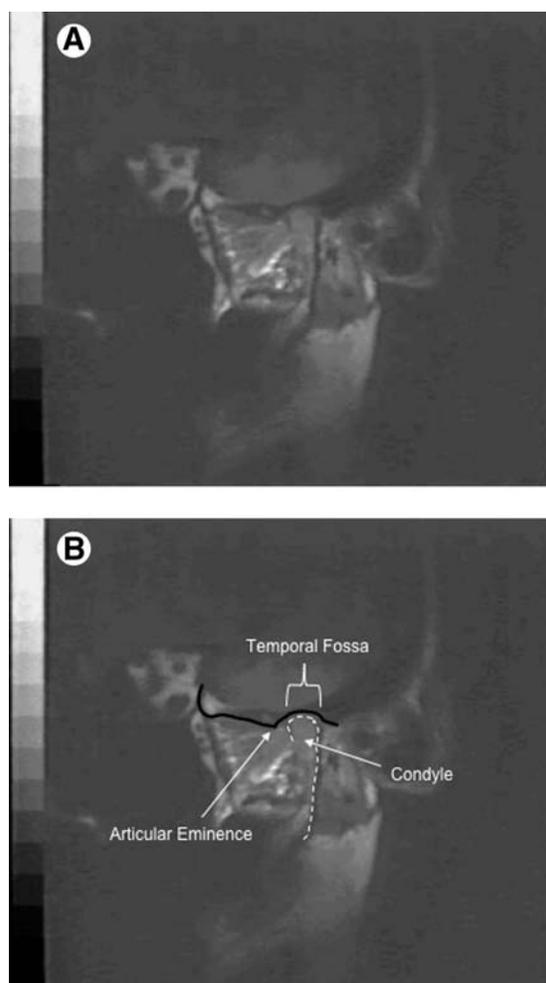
(A) Postoperative MRI of the TMJ in a closed position showing formation of rudimentary elements of a new TMJ. Note a more defined temporal fossa, condyle and articular eminence with an improved anatomical relationship between them. (B) Outline and labels for A.
